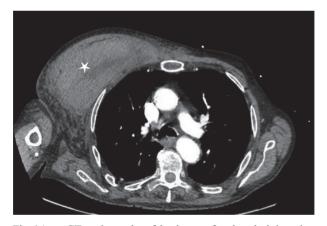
CT angiography of the thorax after the administration of intravenous contrast (arterial phase) showing a hyperdense hematoma in the right pectoral region (white star).
